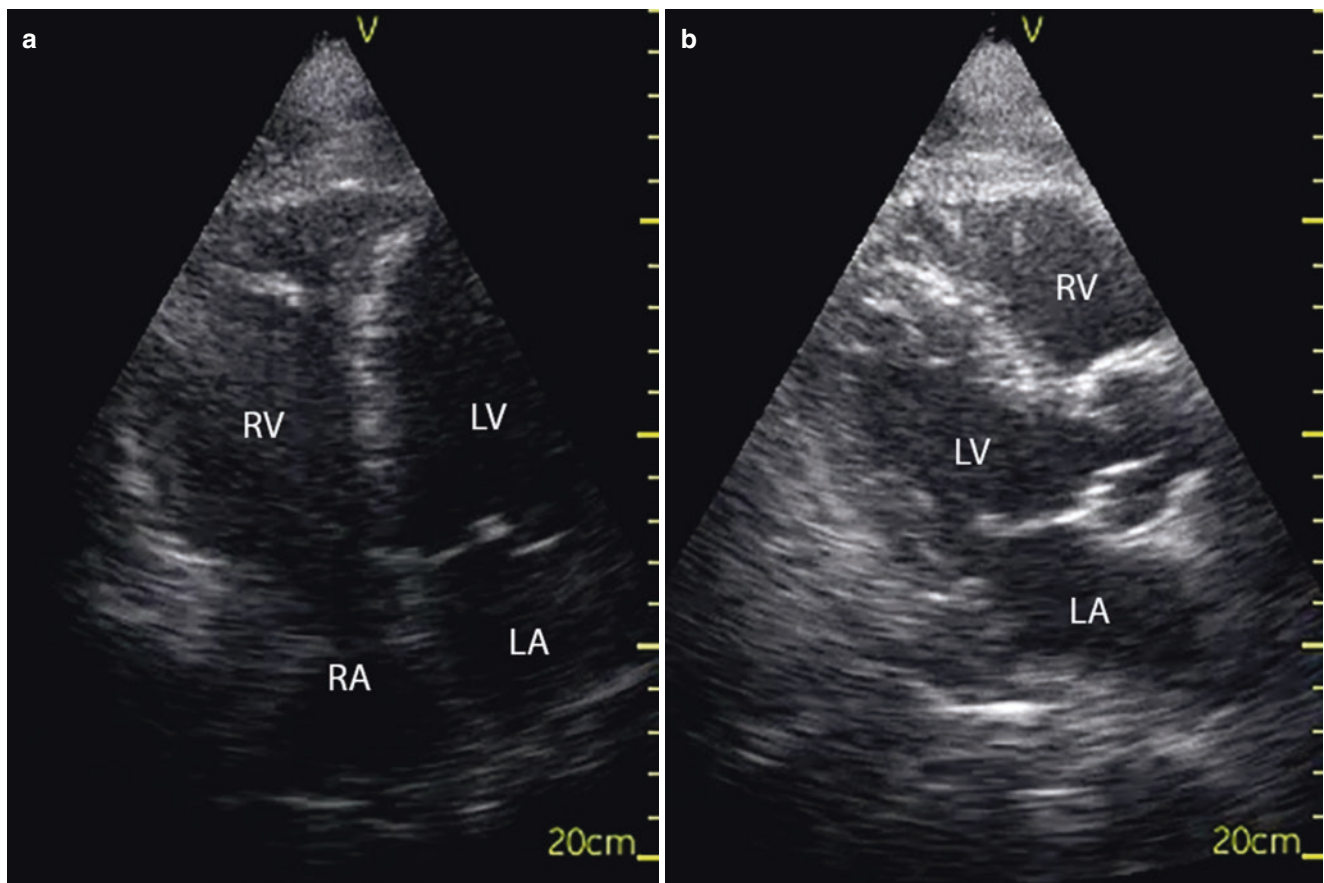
(a) Four chamber view demonstrating right ventricular enlargement and impaired systolic function. (b) Parasternal long axis view demonstrating enlarged, hypokinetic right ventricle
